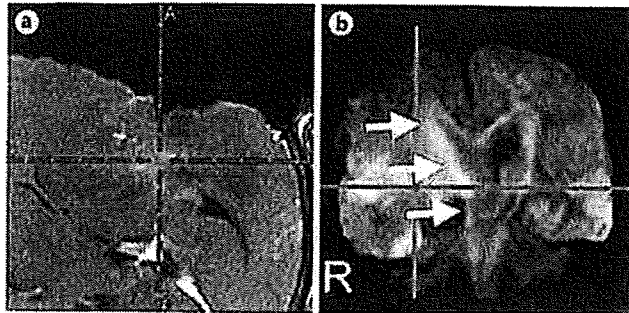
Navigation images based on intraoperative MR imaging of a 68-year-old female with a glioblastoma when a negative response was obtained after subcortical stimulation. a Contrast-enhanced T_1 -weighted axial images. b DW coronal image. The stimulation site directed by a crosshair cursor was located 18.7 mm away from the tract (arrows) on the DW image.
